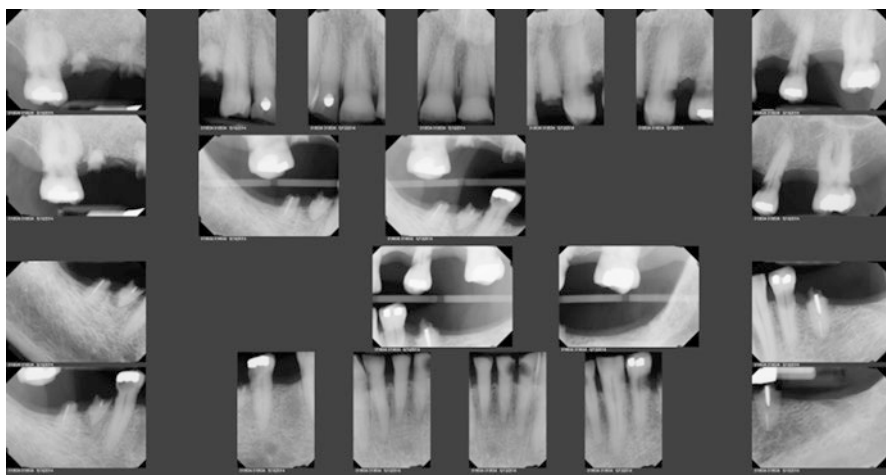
Periapical radiographs of a patient with multiple interproximal and cervical tooth decay. Note teeth that have broken off because of advanced decay
